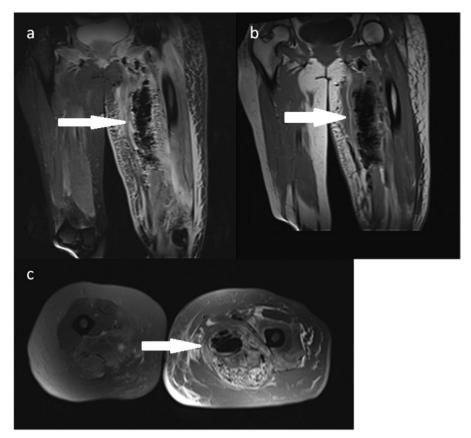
December 22, 2019: (a) MRI coronal T2 fat saturation of both thighs: Extensive edema and inflammatory changes from the upper portion of left gluteus muscles to the lower portion of the leg involving posterior and anterior thigh muscles and adductor magnus, accompanied by a large collection of air in adductor magnus and hamstring muscles with subcutaneous edema containing some gas bubbles (Arrow indicates gas formation). Bone was not involved. (b) MRI coronal T2W of both thighs (Arrow indicates gas formation). (c) MRI axial T2 fat saturation of both thighs. (Arrow indicates gas formation).
